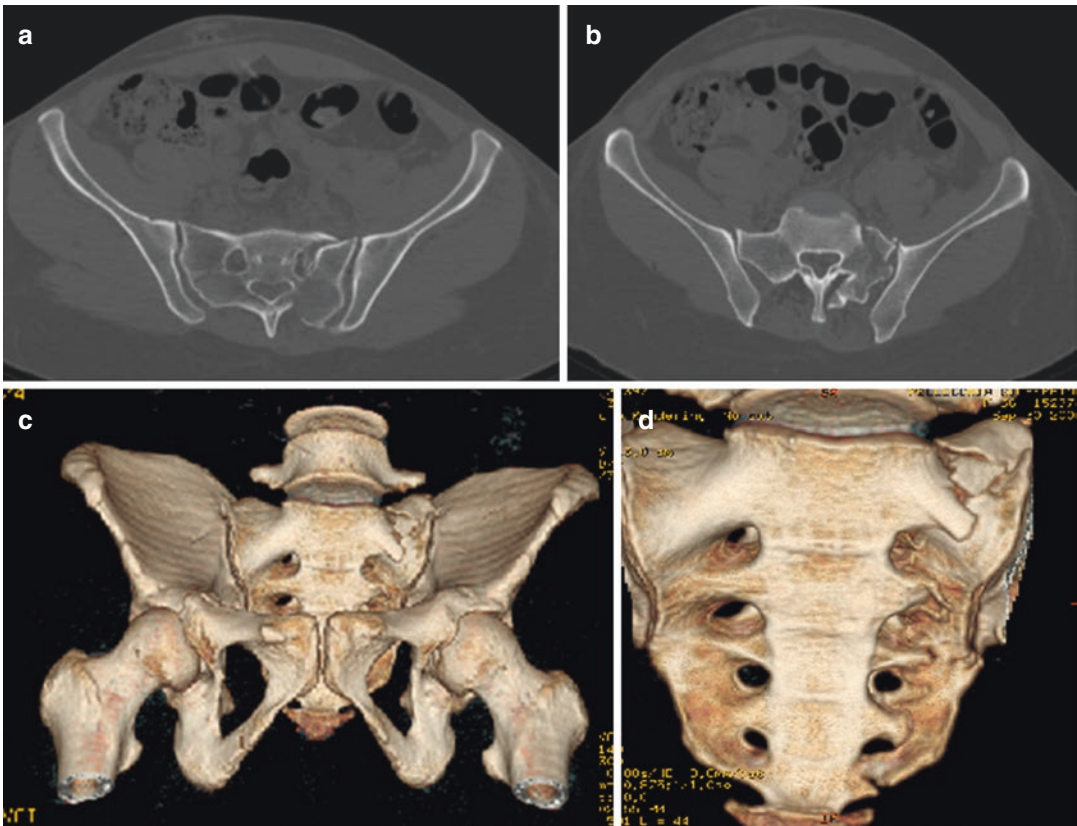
(a–d) Fracture of the sacrum. CT axial view (a, b) and CT 3D (VR) reconstruction AP (c) and posterior view (d) show fracture of the sacrum along the course of the foramina, without involving the spinal canal
